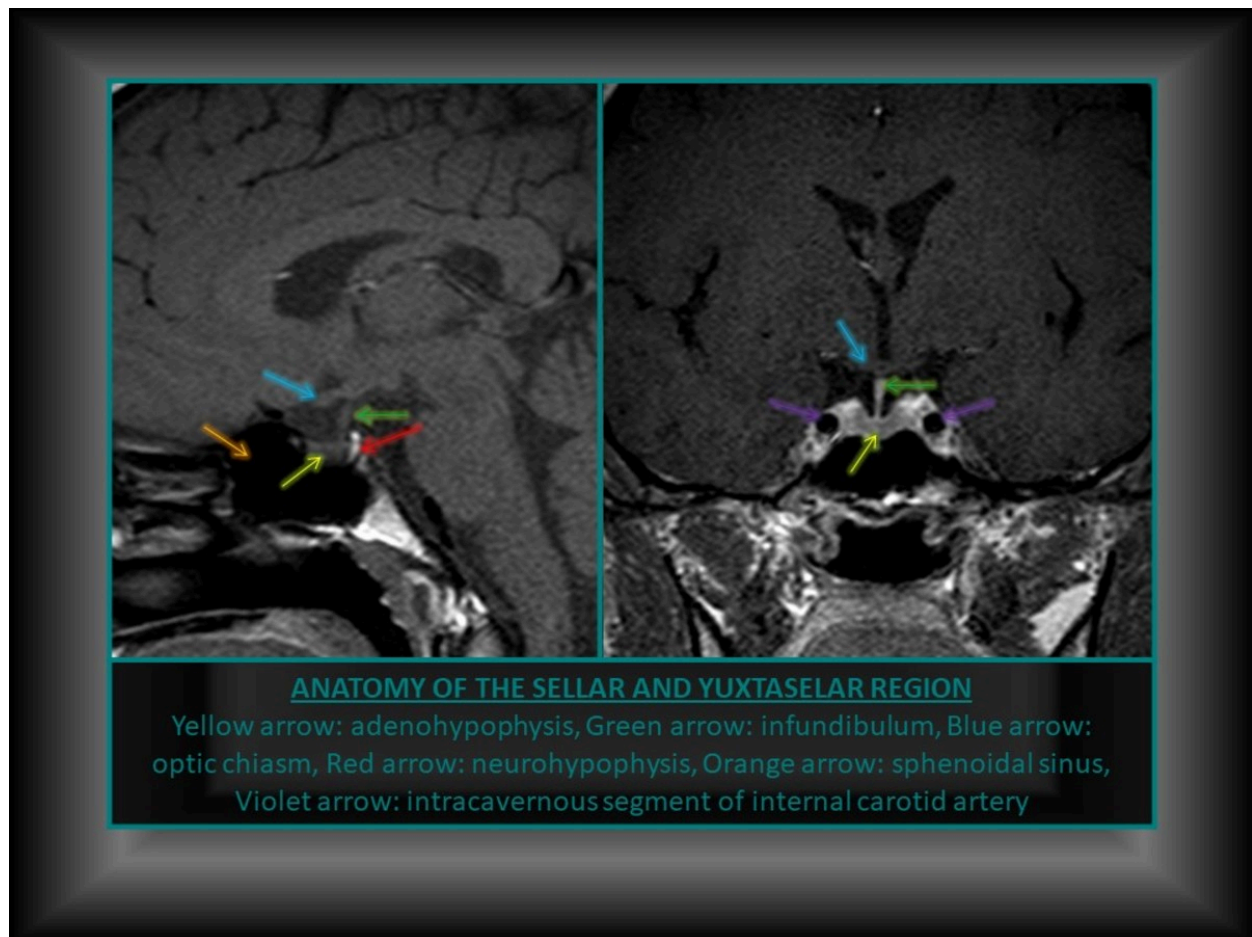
ANATOMY OF THE SELLAR AND YUXTASELAR REGION. Sagittal T1 MRI (a) and coronal T1 MRI (b) with overdrawn scheme of the main anatomical relations.
